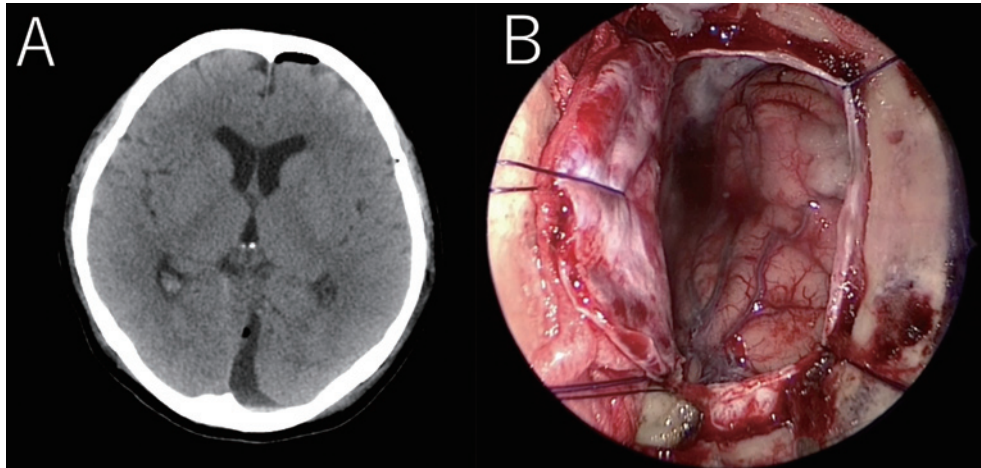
(A) Postoperative computed tomography (CT) image and (B) postprocedural endoscopic image showing mild retraction of the occipital lobe.
